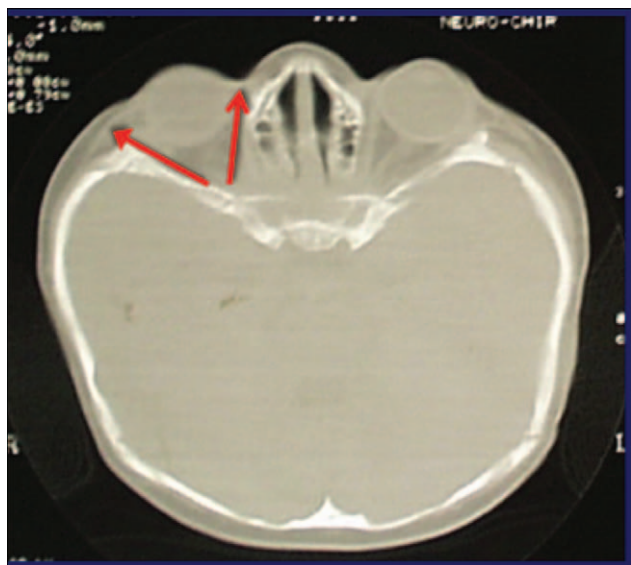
Computed tomography scan of an unoperated patient with Apert syndrome demonstrating shallow orbits with thin diverging external walls. Notice the brachycephalic anteroposterior shortening of the skull.
